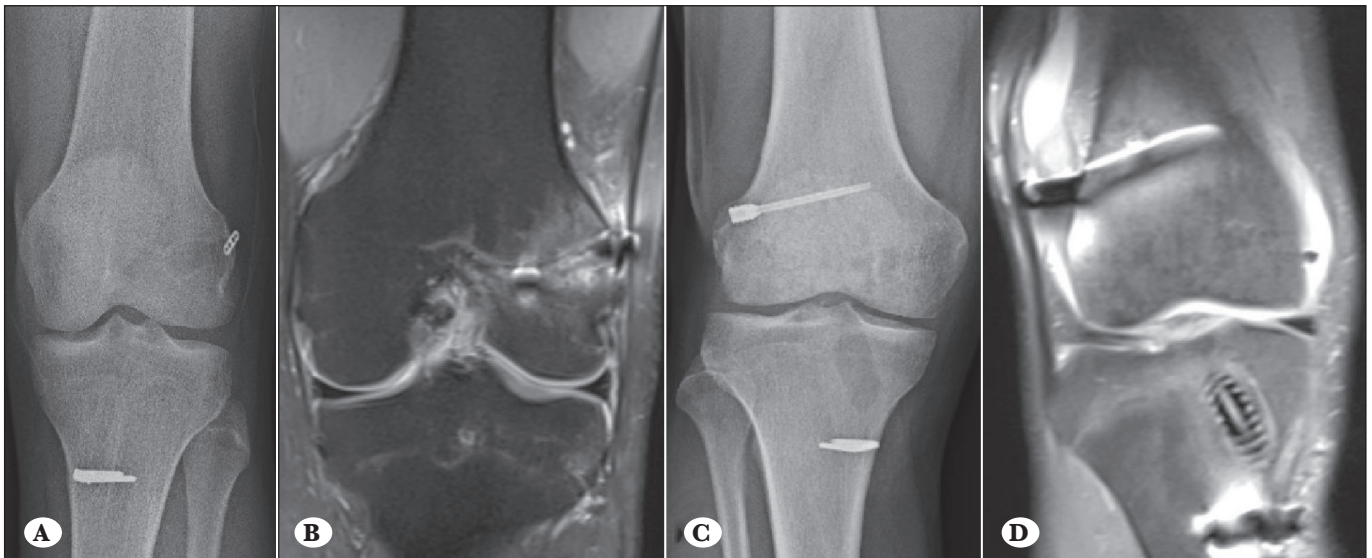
(A) A-P X-Ray image showing endobutton displacement (B) and the same patient's coronal PD-weighted fat suppressed MR image showing endobutton displacement was contacting the adjacent iliotibial band and causing frictional minimal thickening and increased signal intensity. (C) Anterior-posterior X-Ray image showing that a metal transfix device was used as an external fixator, (D) and a transfix device was contacting and protruding laterally the iliotibial band, and causing frictional thickening and increased minimal signal intensity.
